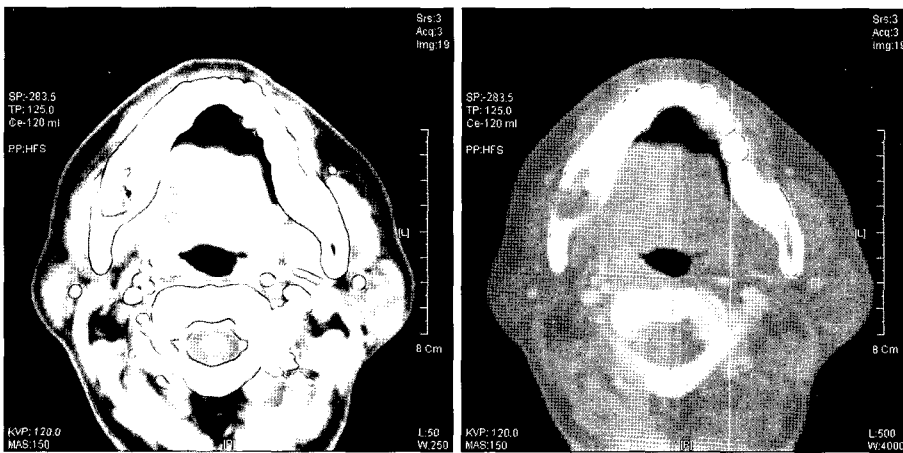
Contrast-enhanced axial CT scans show the perforation of labial cortical plate of the mandible and the contrast-enhanced soft tissue mass extending through the labial cortical plate of the mandible into adjacent soft tissue.
